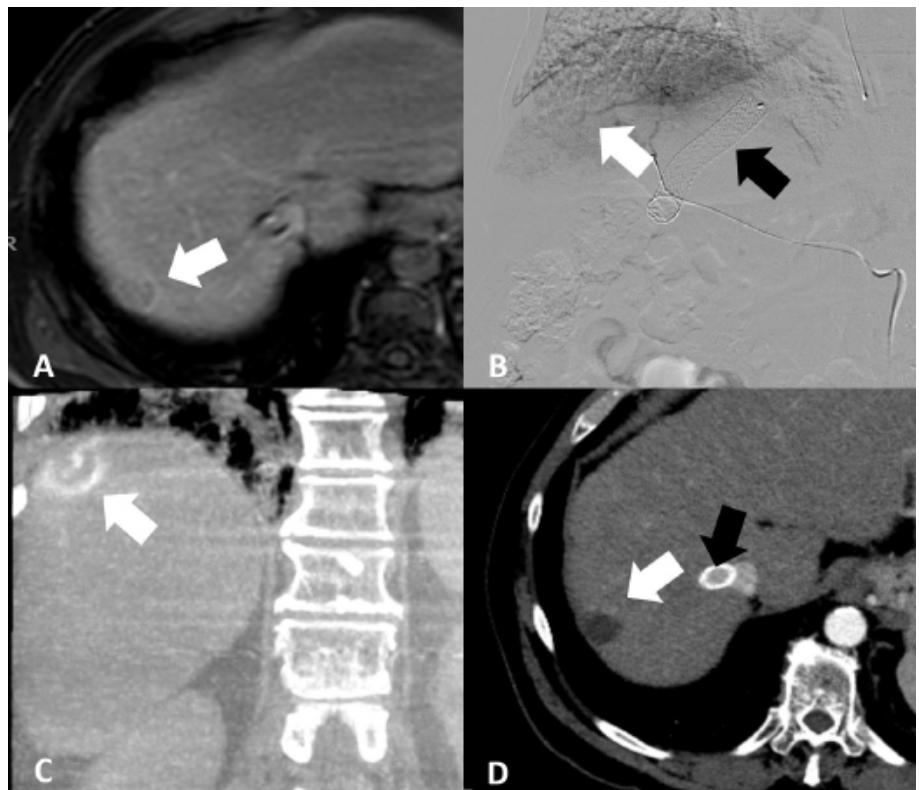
A 63-year-old man with cirrhosis secondary to hemochromatosis. (A) Axial slice from a T1-weighted, contrast-enhanced magnetic resonance imaging scan in portal venous phase demonstrates a 2.1 cm hepatocellular carcinoma (white arrow) in segment 7. (B) Digital subtraction angiogram from a branch of the right hepatic artery during drug-eluting bead chemoembolization (DEB-TACE) does not demonstrate obvious tumor vascularity. A transjugular portosystemic shunt (TIPS) stent is seen (black arrow). (C) Coronal reformatted image from a cone-beam computed tomography performed after DEB-TACE confirms tumor targeting with the embolic agent (white arrow). (D) Axial slice from a contrast-enhanced computed tomography in arterial phase demonstrates no residual enhancement in the tumor (white arrow), consistent with a complete response. The patient underwent successful liver transplantation approximately 10 months later. The TIPS stent is also seen (black arrow).
